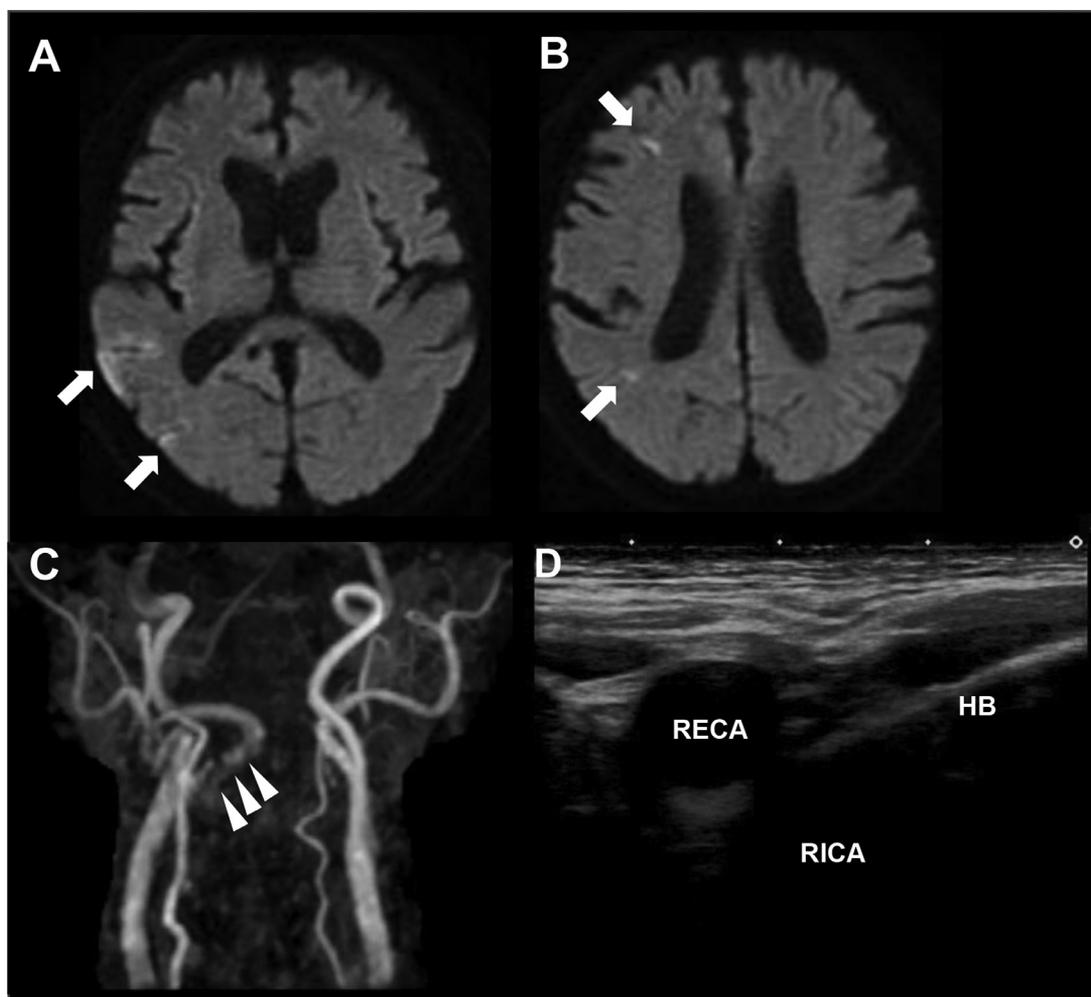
Brain and cervical magnetic resonance imaging on admission. Diffusion-weighted images showing high intensities in the territory of the right middle cerebral artery (A, B, arrows). Cervical magnetic resonance angiography showing tortuosity of the right proximal internal carotid artery running medially into a retropharyngeal location (C, arrowheads). On transverse B-mode imaging of carotid ultrasonography, the proximal right internal carotid artery (RICA) was not visualized because of the acoustic shadow from the hyoid bone (D). HB, hyoid bone; RECA, right external carotid artery.
